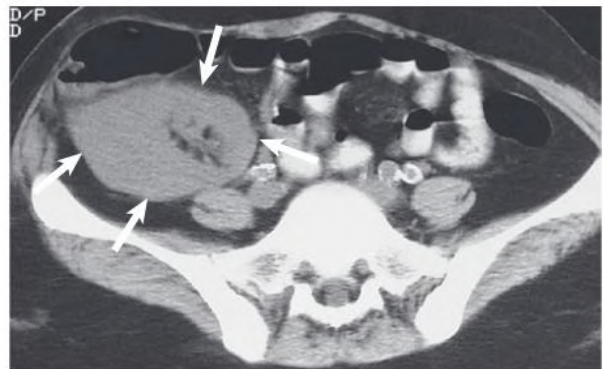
Normal kidney transplant (*arrows*) on computed tomography.
